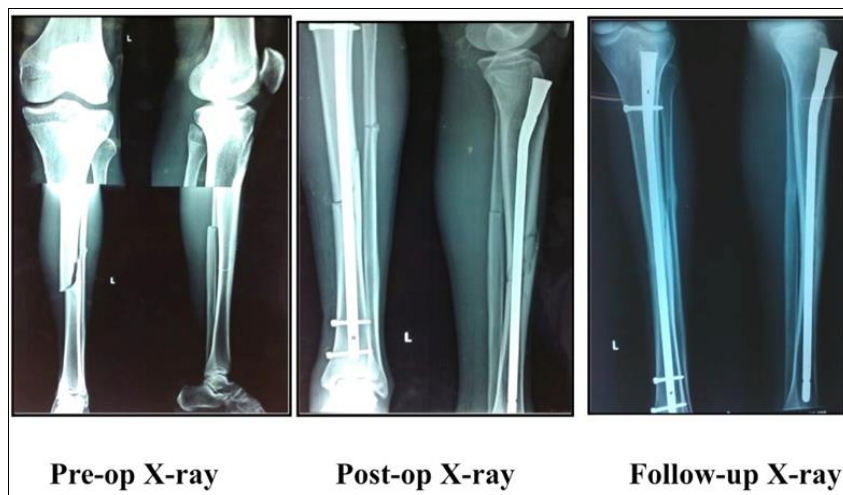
Radiographs of pre-op, post-op and followup of a case
